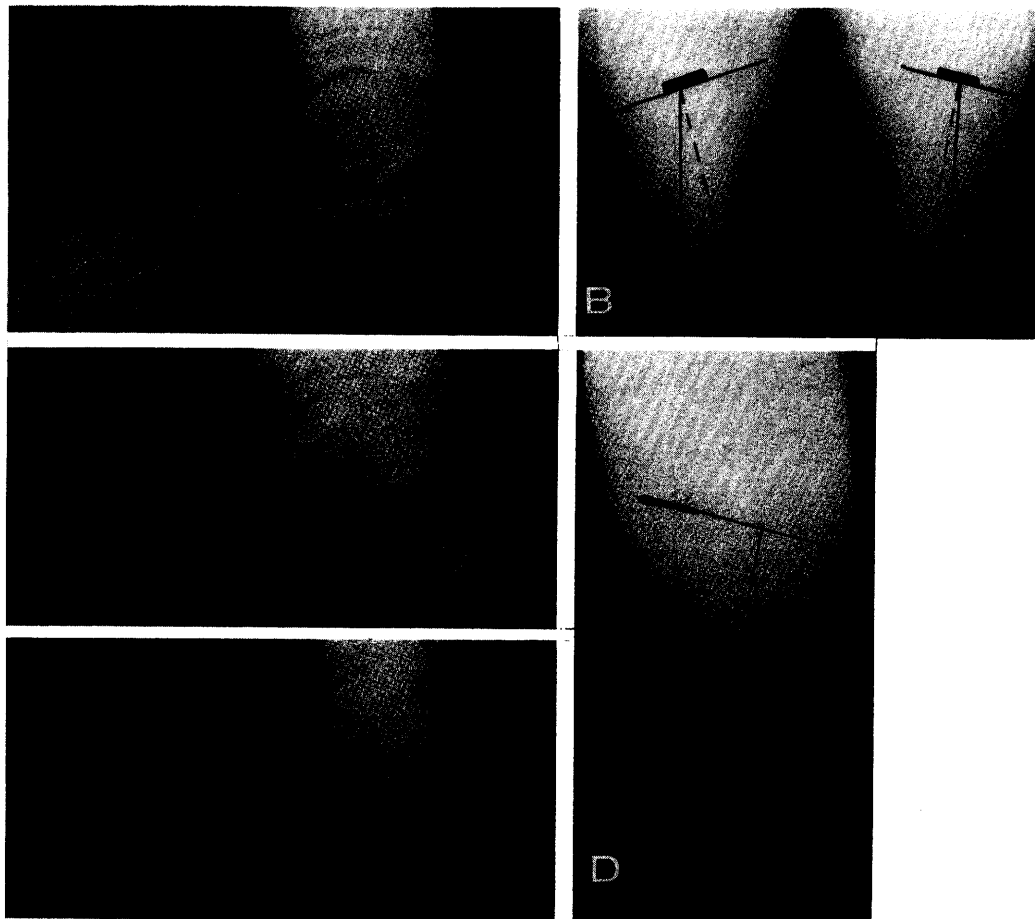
Varus osteotomy of the calcaneus. A, preoperative lateral x-ray. B, preoperative tangential view of the calcaneus demonstrating a true valgus torque to the posterior tubercle of the calcaneus. C, postoperative x-ray—varus osteotomy of the calcaneus. (Note bone graft in place.) D, postoperative tangential view of varus osteotomy of the calcaneus. E, postoperative lateral x-ray 7 months postoperatively.
